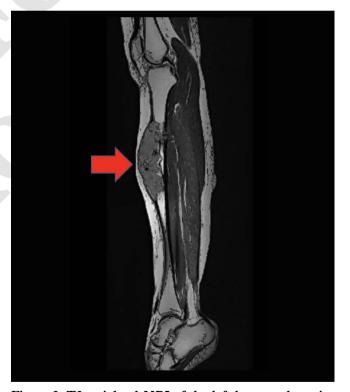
T2-weighted MRI of the left leg reveals an intraosseous heterogeneous hyperintense mass (red arrow), measuring $3.2 \times 3.7 \times 12.3$ cm over the anteromedial aspect of proximal and mid diaphysis of the left tibia. This mass is exophytic and causes cortical destruction at the anterior and medial aspects of the left tibia. However, the mass is completely enclosed by the periosteum of the tibia. No breach of periosteum nor extension into the adjacent tissue or knee joint was identified.
